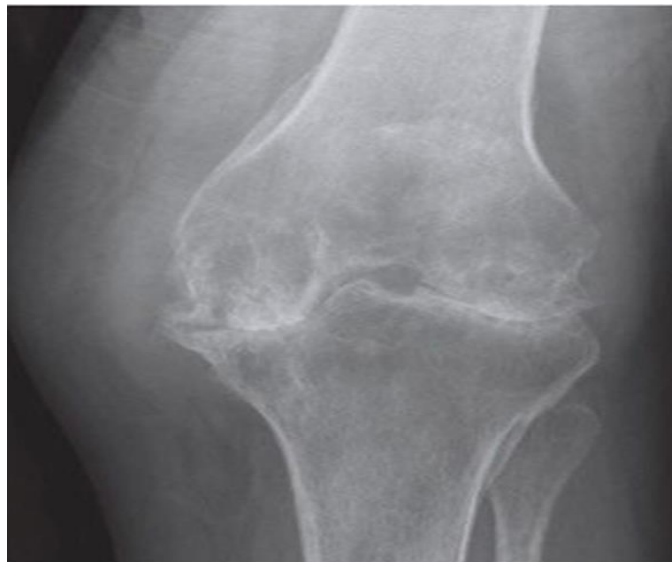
A knee anteroposterior radiograph showing osteoarthritis with infection
